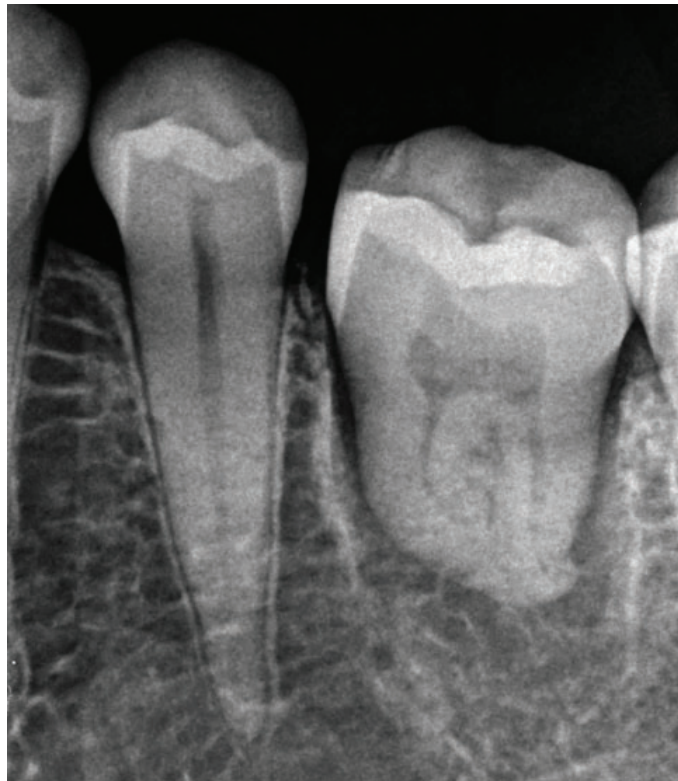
Periapical X-ray immediately after transplantation.
